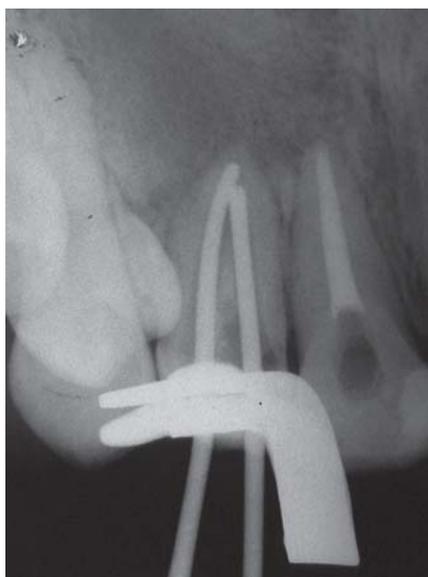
Radiograph showing main gutta-percha cones
